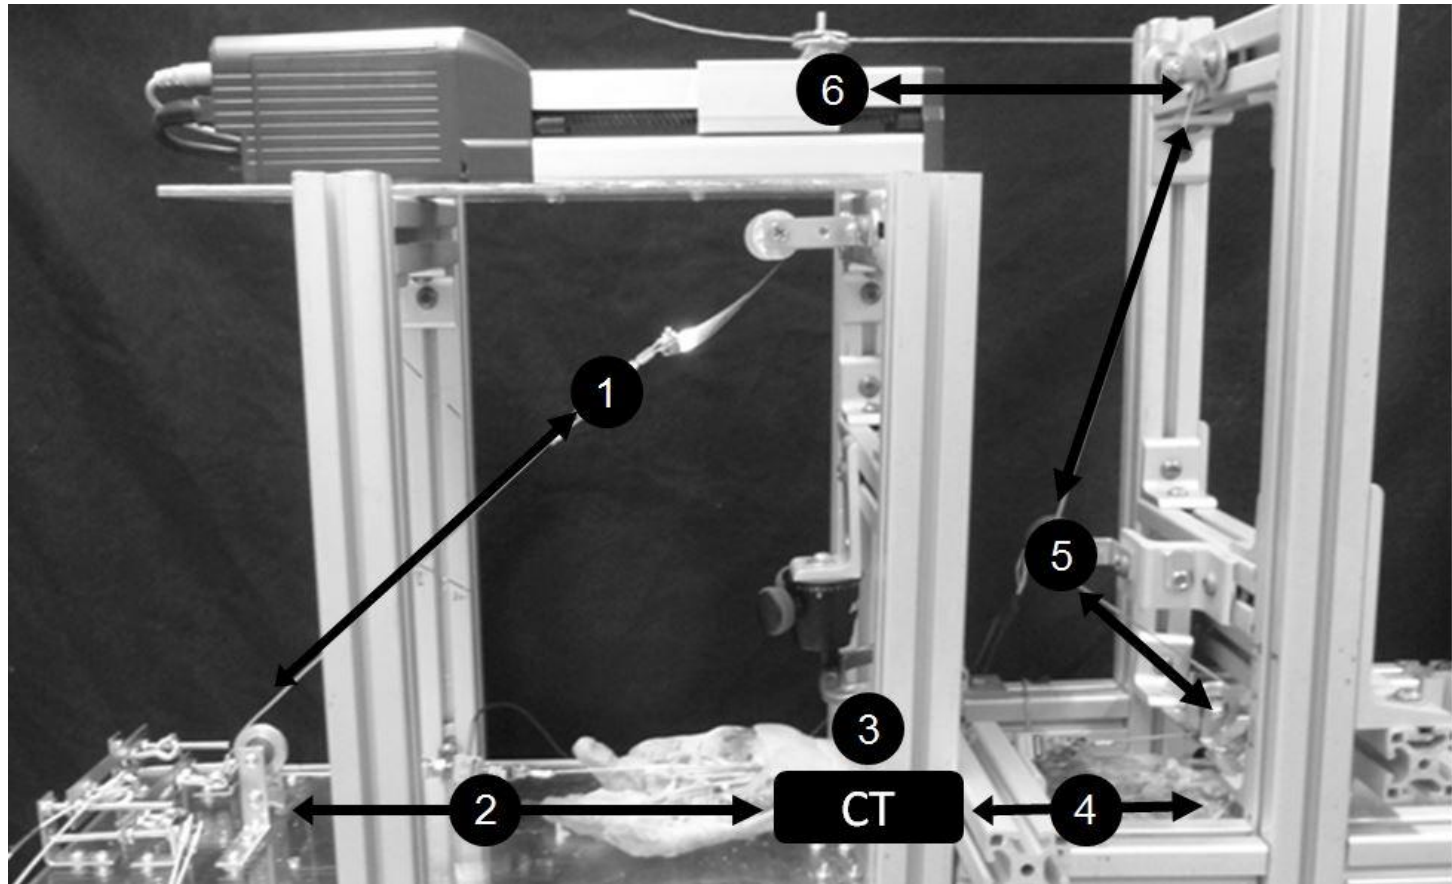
A cadaver forearm in the testing apparatus. The tendon line is connected to the middle FDS tendon and moves in the proximal-distal directions as indicated by the arrows. The tendon line consists of a (1) constant force spring, (2) distal force sensor, (3) ultrasound probe, (4) proximal force sensor, (5) potentiometer, (6) mechanical actuator. CT indicates the location of the carpal tunnel.
